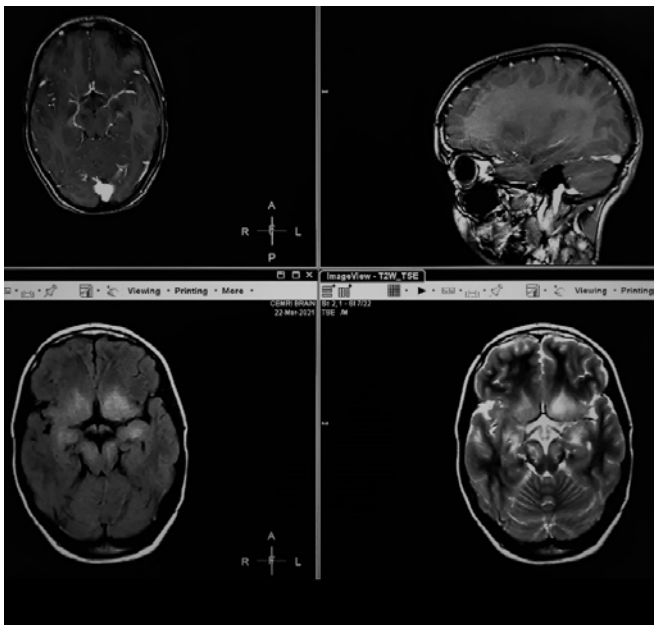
Herpes Simplex Encephalitis. T2, FLAIR hyperintensities In bilateral basifrontal regions, MTLs and midbrain regions.
